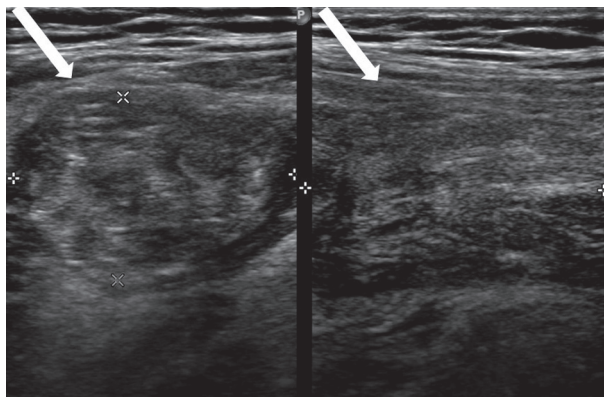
Ultrasonography performed at the Emergency Department with muscle rupture (arrows)
